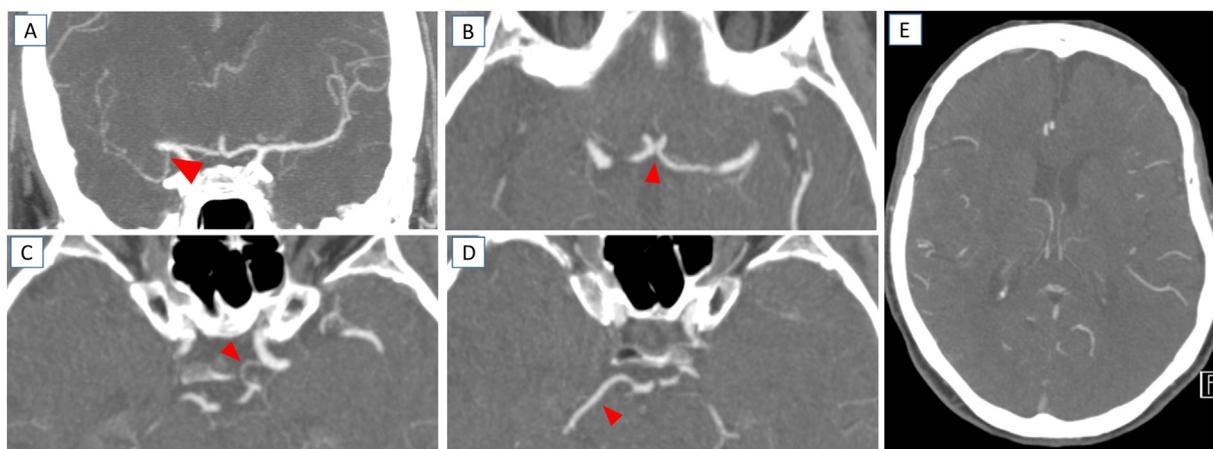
CT angiography showing acute occlusion of the proximal portion of the middle cerebral artery on the right side and patency of the anterior temporal artery (Panel A). The cross-flow through the anterior communicating artery and contralateral posterior communicating artery (PCoA) is visible (Panel B, C). However, ipsilateral PCoA is absent (Panel D). Example of good leptomeningeal collaterals (Panel E).
